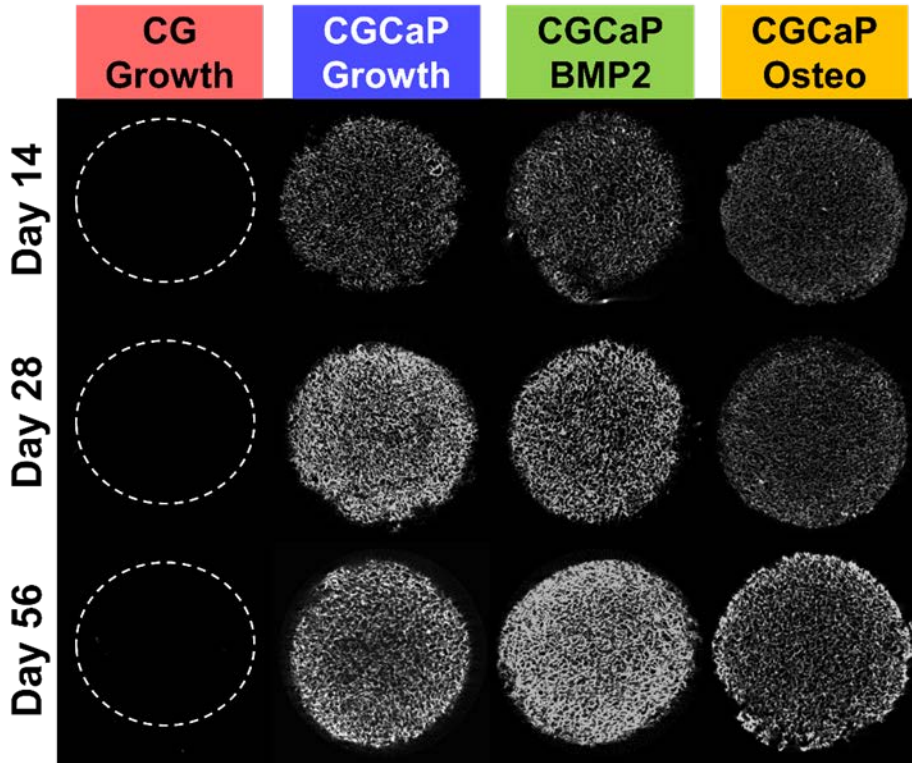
Mineral content via micro-computed tomography within scaffolds.
